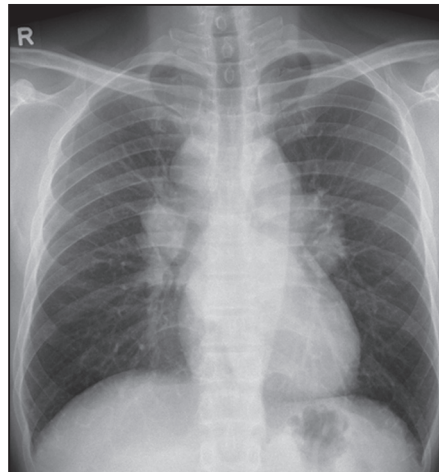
Frontal chest radiograph of the patient taken at the time of presentation.
